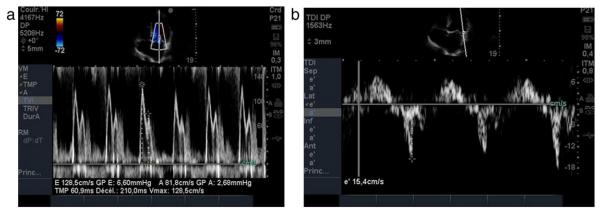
Cardiac ultrasound data: mitral Doppler in pulsed mode and tissue Doppler on the lateral edge of the mitral annulus on the apical 4 chamber view.
